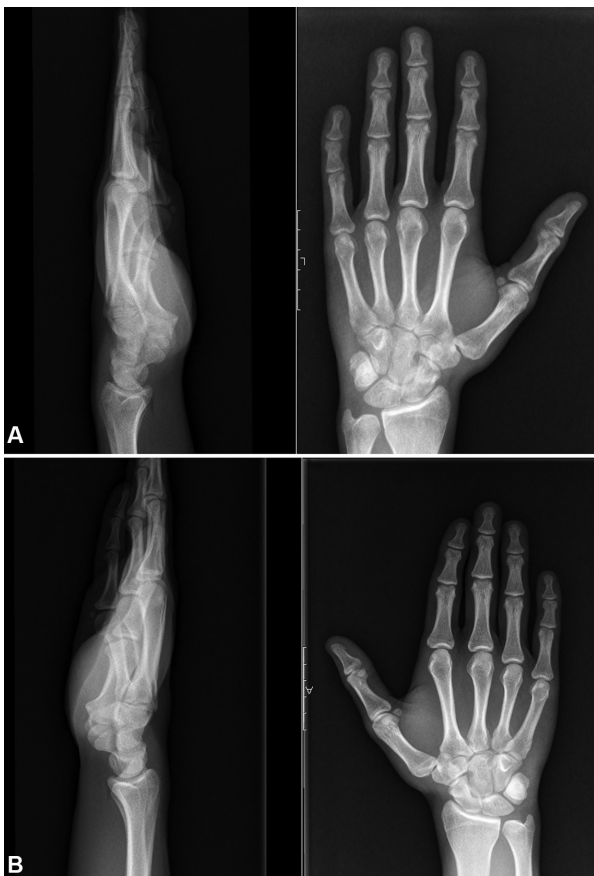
(A) Radiograph of the left wrist at 12 weeks postoperatively, revealing the sustained pisiform reduction; (B) Radiograph of the right wrist.
